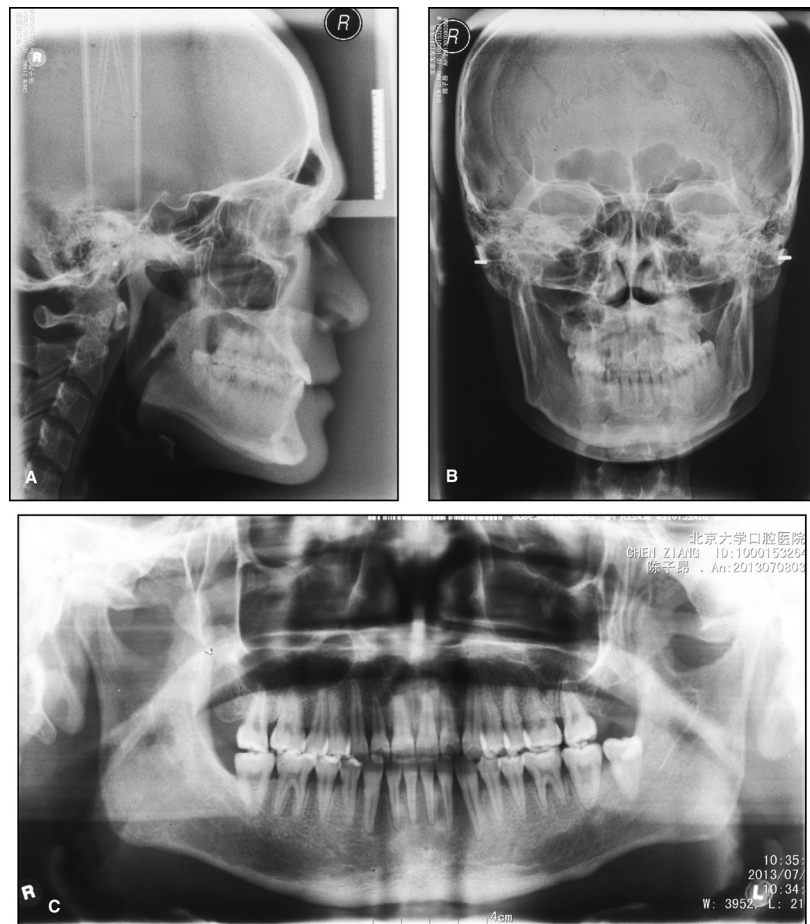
Posttreatment radiographs (titanium plates were removed): A, lateral cephalogram; B, posteroanterior radiograph; C, panoramic radiograph.
